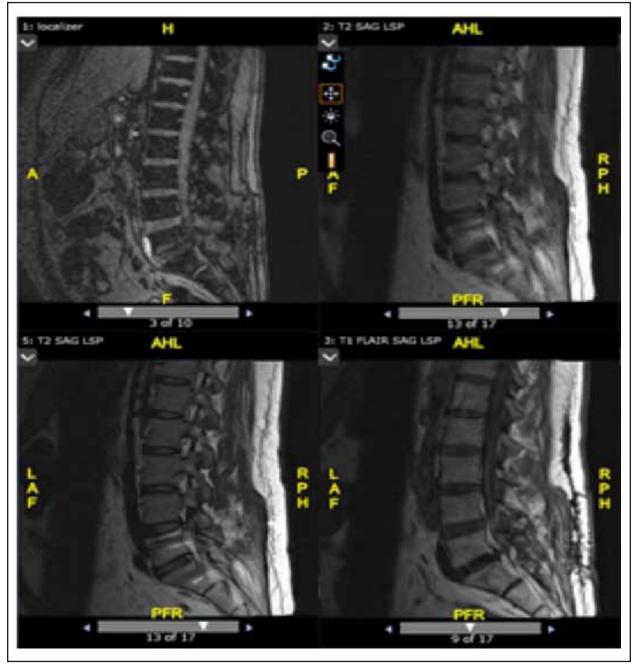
MRI images following intrathecal bleed.
